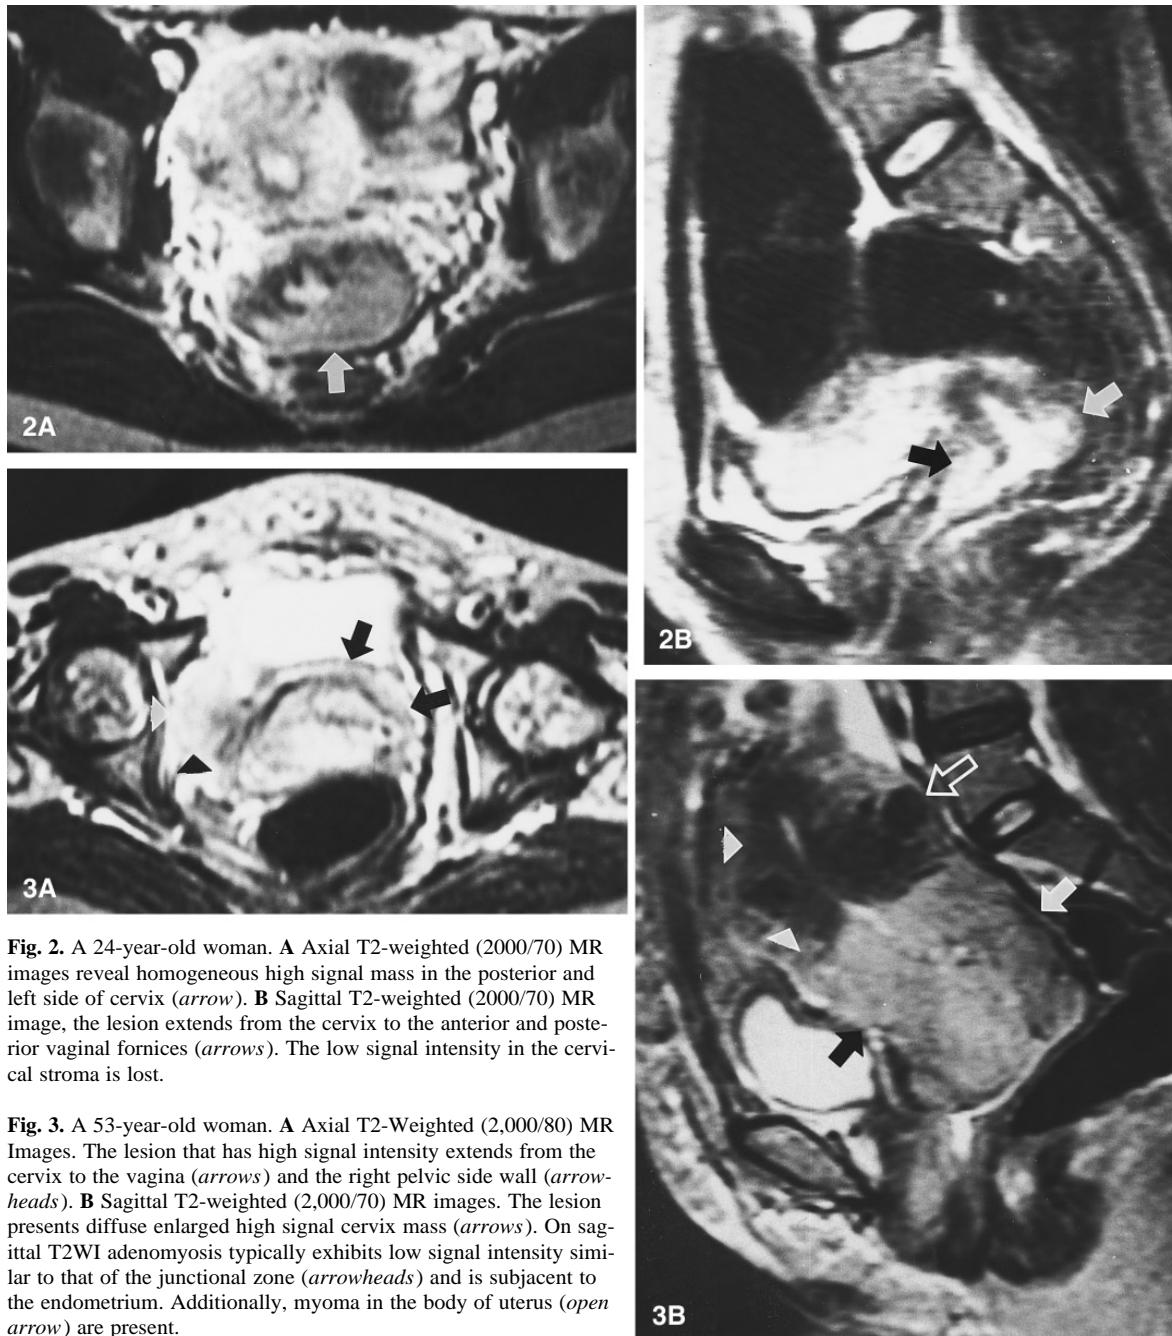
A 24-year-old woman. A Axial T2-weighted (2000/70) MR images reveal homogeneous high signal mass in the posterior and left side of cervix (*arrow*). B Sagittal T2-weighted (2000/70) MR image, the lesion extends from the cervix to the anterior and posterior vaginal fornices (*arrows*). The low signal intensity in the cervical stroma is lost.
